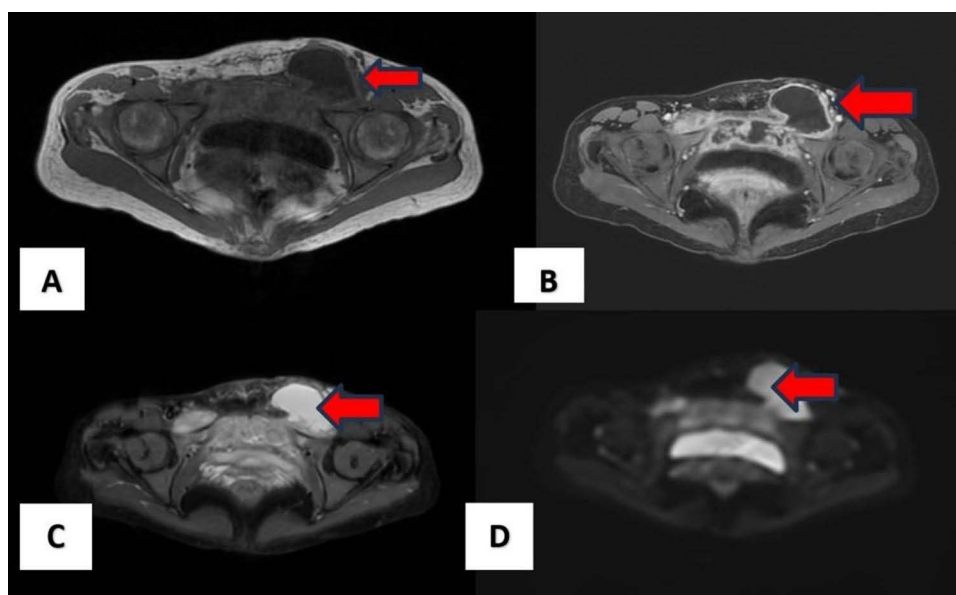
Abdominal MRI of The Left Pelvic Region. Abdominal MRI dated November 2025 shows a T1-weighted (T1/WI) hypointense (A), T1+Contrast (B), T2 -Stir (T2/WI) weighted hyperintense (C) and restricted diffusion of DWI images and RIM enhancement after contrast administration in the left pelvic region (D), involving the pelvic muscles and extending to the left anterior abdominal wall, impression more likely tuberculosis of the pubic symphysis with a left pelvic abscess (estimated volume 190 cc) (Red arrow).
